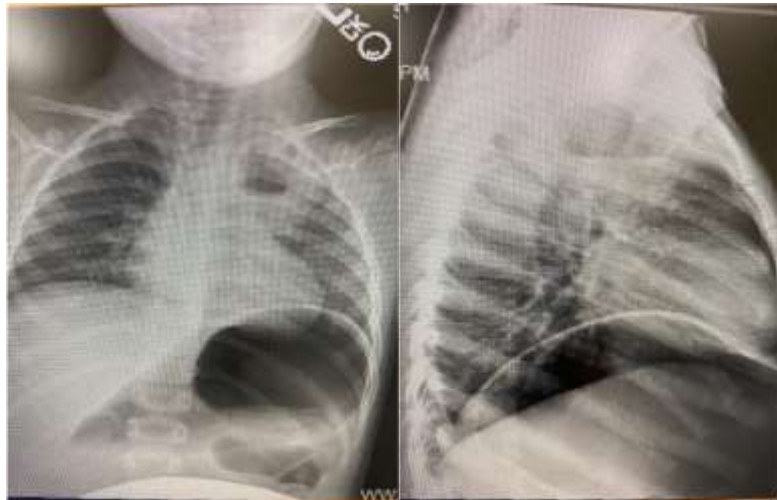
Plain radiograph of the patient's chest during initial admission revealing left upper lobe consolidation
